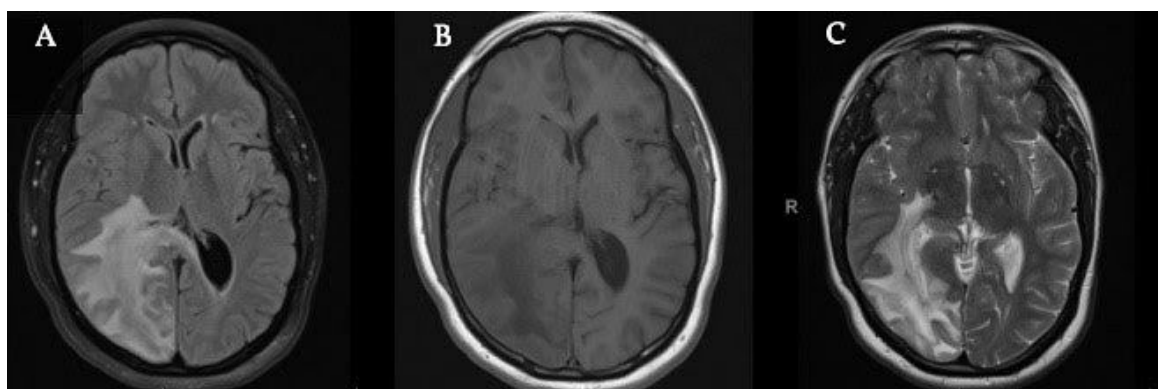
Patient 6 MRI Imaging. (A) Axial Flair (B) Axial T1 (C) Axial T2. MRI Imaging shows a 6.7 x 3.2 cm tumefactive demyelinating lesion of the left temporal-parietal lobe. Significant surrounding edema is seen in the posterior right cerebral hemisphere and splenium of the corpus callosum
